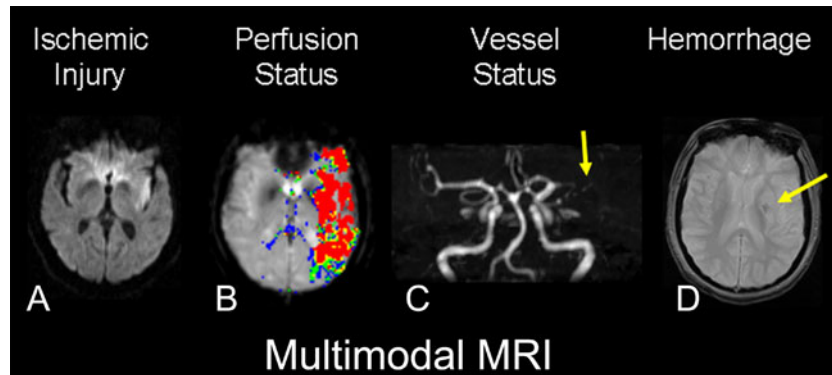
Example of multimodal MRI in acute stroke: (A) DWI showing hyperintense ischemic region in the left insula. (B) Tmax perfusion MRI demonstrating left MCA perfusion deficit. (C) Intracranial MRA demonstrating left MCA occlusion (arrow). (D) gradient echo MRI demonstrating small region of hemorrhagic transformation (arrow). MRI = Magnetic resonance imaging; DWI = diffusion-weighted MR; MCA = middle cerebral artery. With kind permission from Kidwell and Wintermark [62, figure 1, page 22]. Copyright, Springer Science and Business Media. (High resolution version of this image is available in the [electronic supplementary material](#).)
